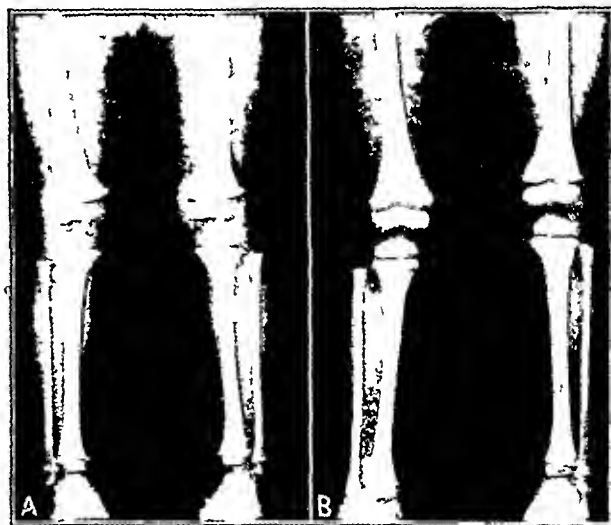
A dense transverse bands at the growing ends of the long bones observed in a child with lead poisoning. B roentgenogram of the long bones of the same patient four months later. Note the greater breadth of the bands.
